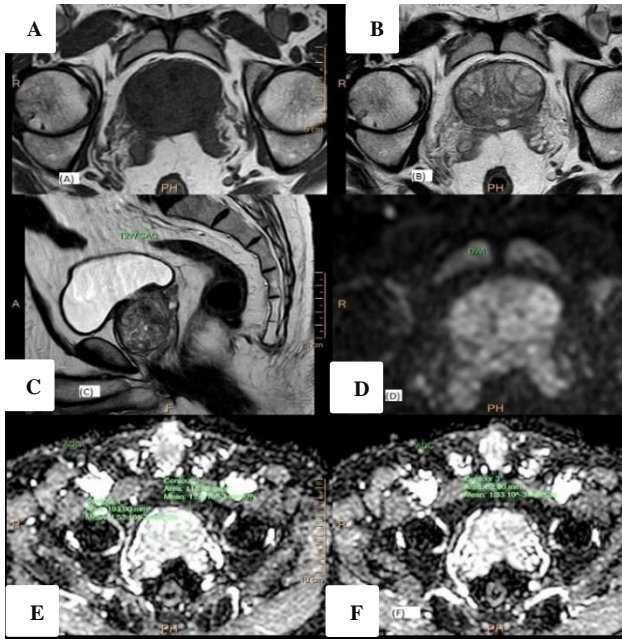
MRI of BPH, (A) Hypo-intense on T1Wi, (B, C) Enlarged transitional zone with heterogenous signal intensity on T2Wi, (D) On DWi, no diffusion restriction, (E, F) Corresponding ADC map images show intermediate signals.
